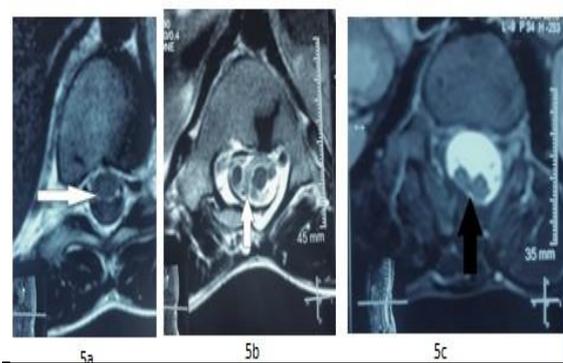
MRI spine axial sections (a) T1W image at D11 level of beginning of splitting of the cord (white arrow). (b) T2W image at the level of split cord (vertical white arrow) (c) T2W image at the level where the cord is reuniting again (black upward arrow).
